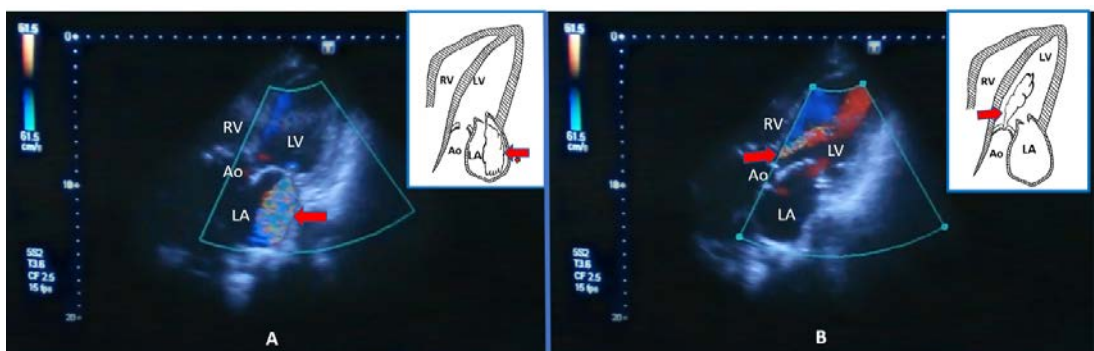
A. Color Doppler echocardiography and scheme. Apical five-chamber position. Turbulent flow in the left atrium during systole reaching the upper wall of the left atrium. The stream of mitral regurgitation is variegated (arrow). B. Colour Doppler echocardiography and scheme. Apical five-chamber position. Turbulent flow in the left ventricular outflow tract and cavity. The stream of aortic regurgitation is colored red (arrow).
